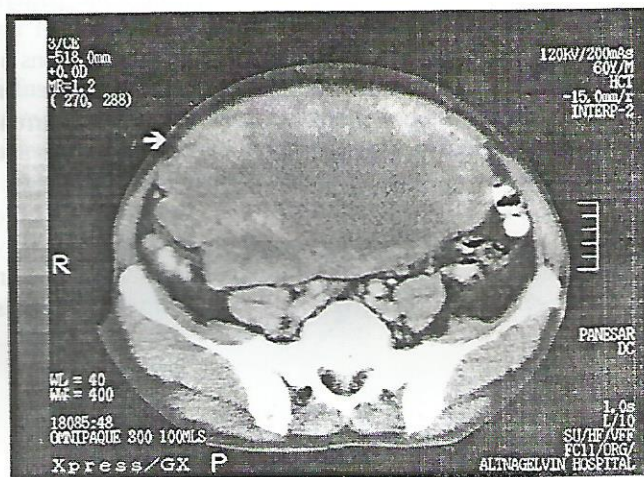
CT showing the huge tumour burden. Note the plane of cleavage at the extreme posterior.
